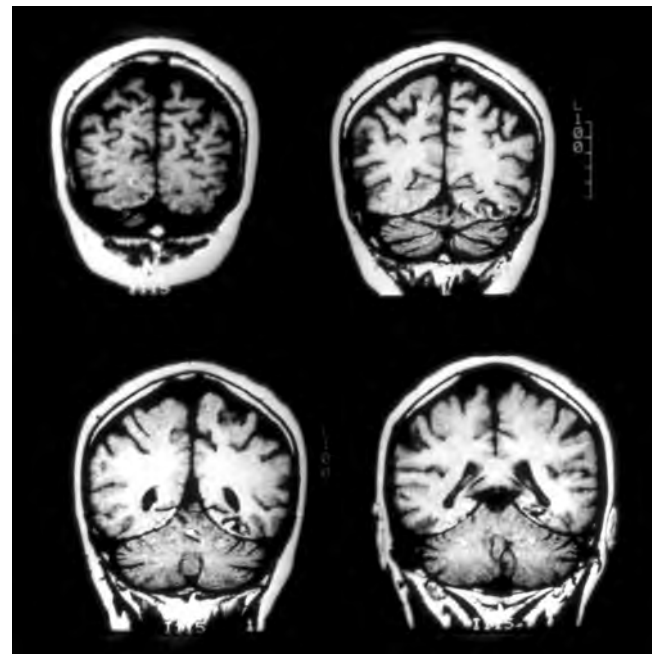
T1 weighted magnetic resonance image (MRI) showing bilateral ventral occipito-temporal infarction. The patient had prosopagnosia and cerebral achromatopsia.
